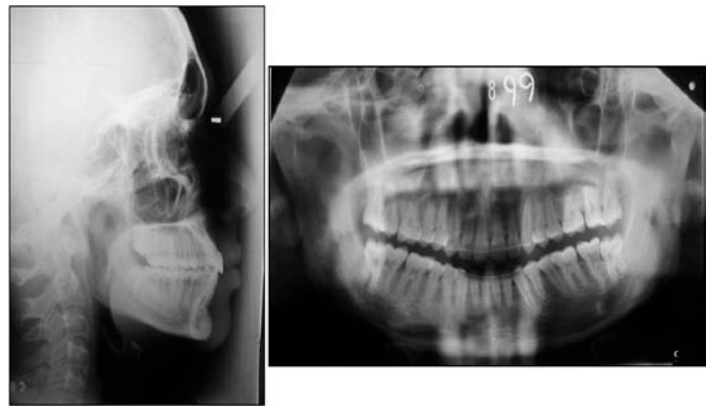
Patient eight years post treatment, radiographs.
